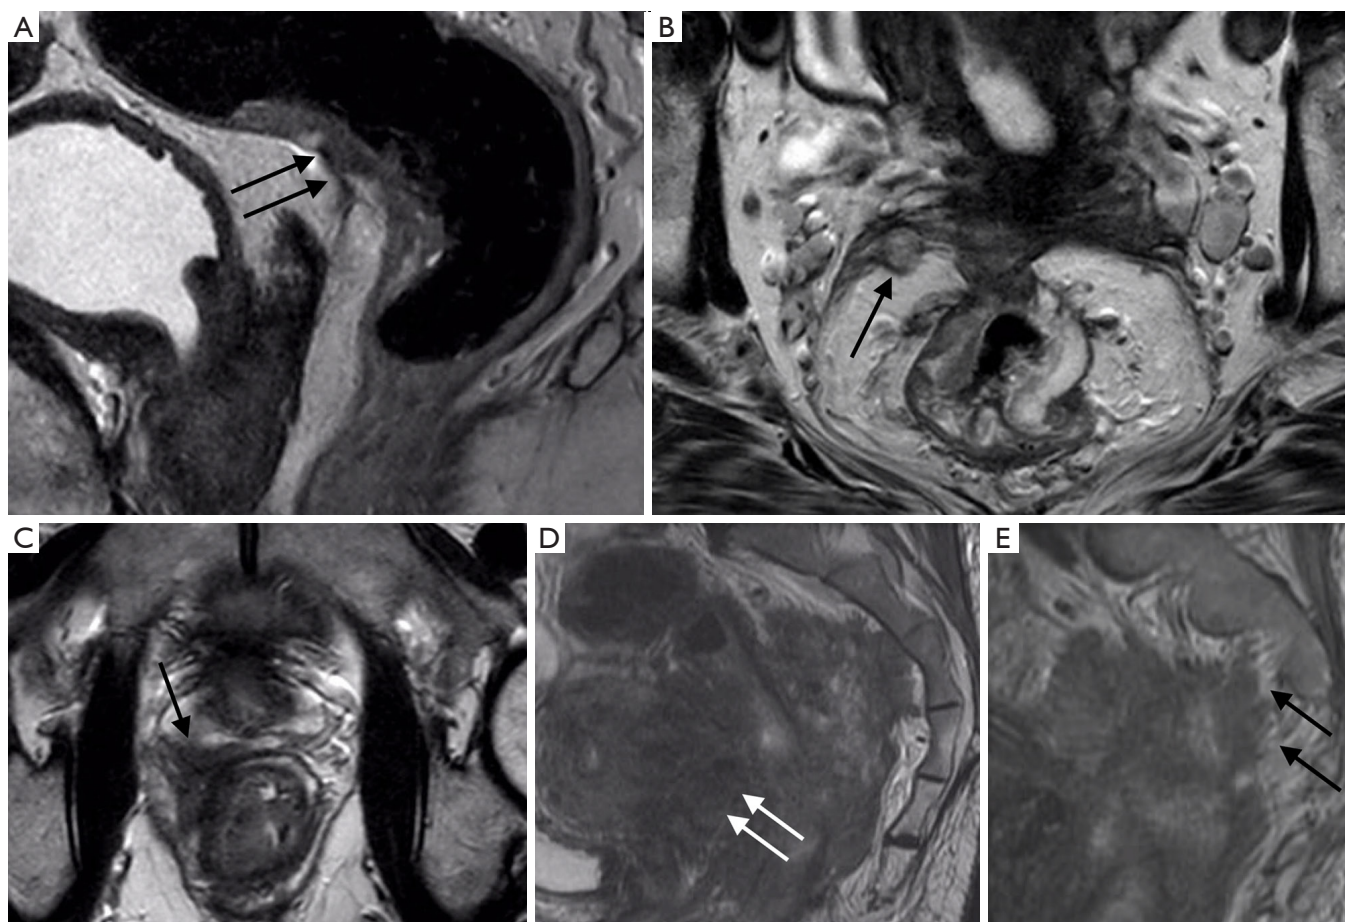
Rectal MRI in four patients: (A) Tumour extends into the peritoneal reflection. (B) mrEMVI involves the peritoneal reflection. (C) Tumour involves the right peripheral zone of the prostate gland. (D) Tumour invades the wall of the uterus and, in the same patient, (E) extends to the presacral fascia, involving the right S2 nerve root. These tumours require pelvic exenteration.
